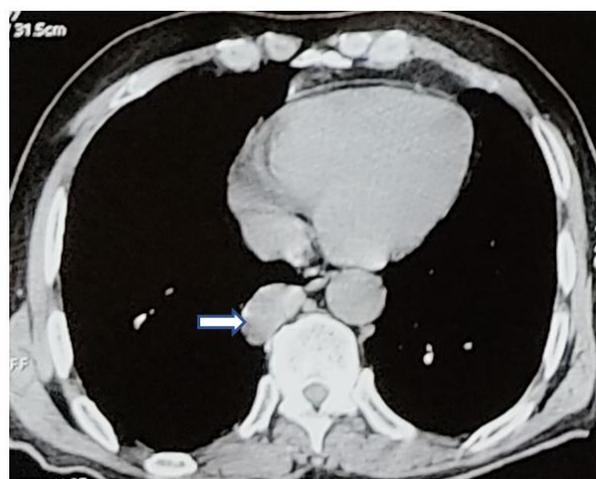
Chest CT scan in mediastinal window without contrast injection, axial slice, showing an oval, well-limited right paravertebral mass with some peripheral calcifications
